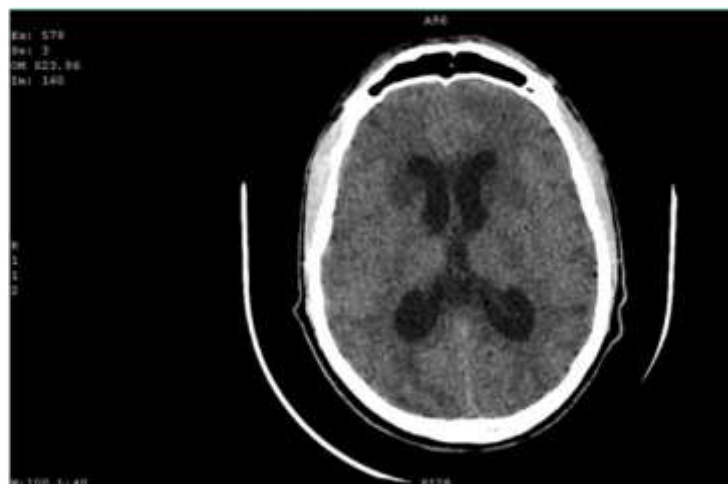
Repeat Brain CT of patient on admission day 8 at the level of the lateral ventricles showing multiple ischaemic infarcts involving the parietal cortices, the heads of cordate nuclei and both internal capsules.
